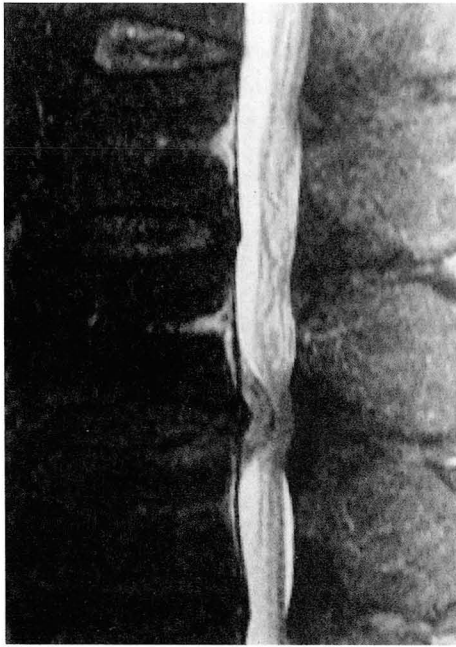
T2-weighted sagittal image shows mild redundancy of nerve roots above the level of severe constriction of spinal canal at L2-3 caused by herniated nucleus pulposus.
